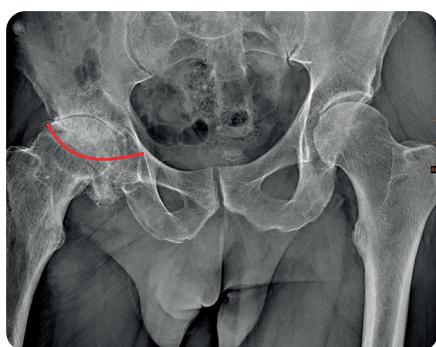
The X-ray image of a patient with right-sided hip osteoarthritis with morphometric exclusion criteria for bone tissue donation (the red line marks the border between the normal and injured area of the femoral head)
